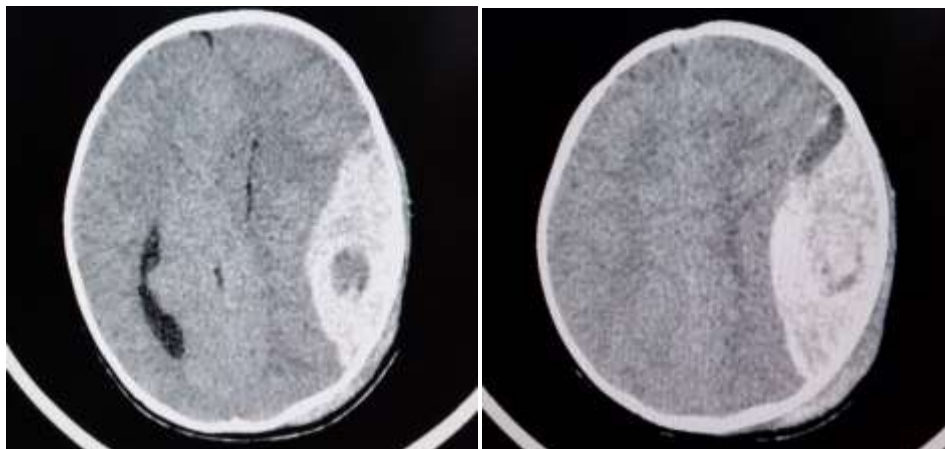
Preoperative CT showing massive Left temporoparietal acute EDH with mass effect with compression of Left lateral ventricle with midline shift.
